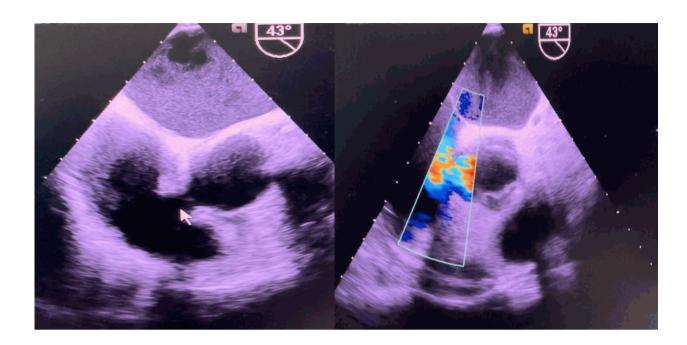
TEE at midesophageal level at 43 degrees showing ruptured noncoronary sinus of valsalva (white arrow). Color doppler showing left to right shunting from ruptured sinus of valsalva to right atrium.
